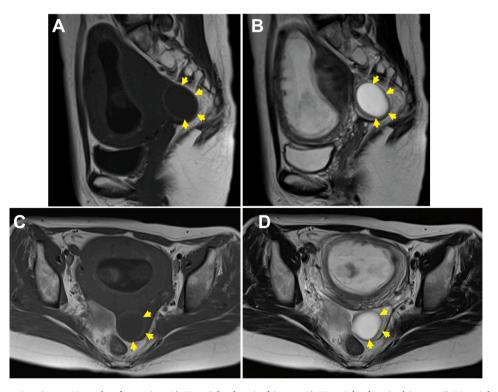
Magnetic resonance imaging at 12 weeks of gestation. A) T1-weighted sagittal image. B) T2-weighted sagittal image. C) T1-weighted axial image. D) T2-weighted axial image. Arrows show a 4-cm tumor in the posterior fornix with low intensity on T1-weighted imaging and high intensity on T2-weighted imaging.
